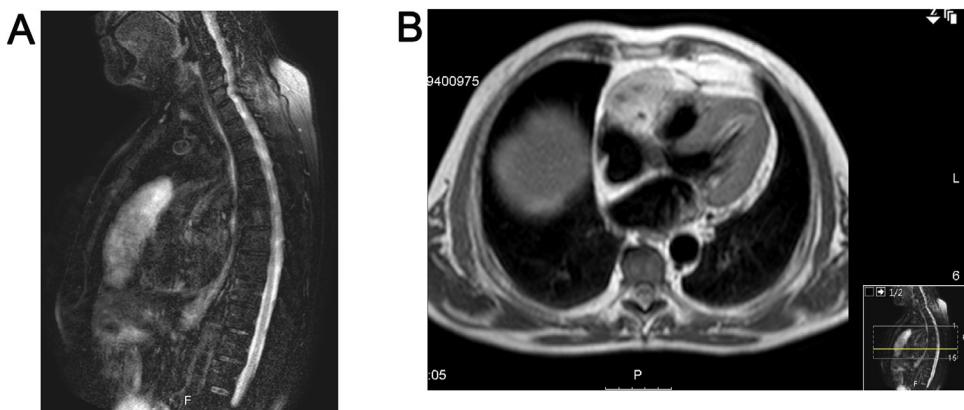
Magnetic resonance imaging in T2 showing the intrapericardial mass with hypersignal (asterisk) surrounding the wall of the right atrium (white arrow) and ventricle (dotted arrow) with apparent cleavage plan. (A) Sagittal section. (B) Axial section.
